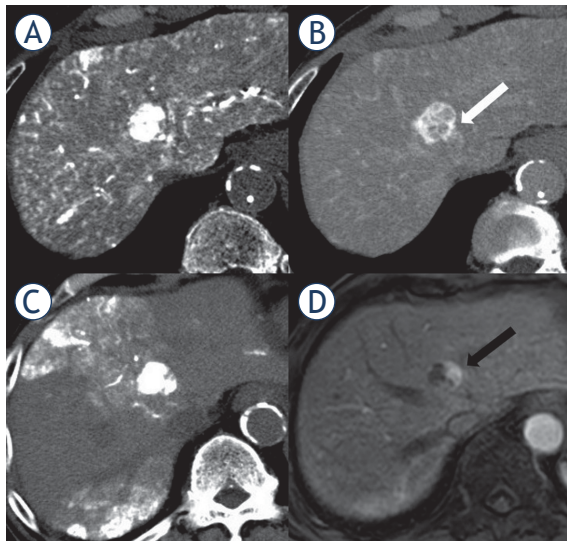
Local tumor recurrence after transcatheter arterial chemoembolization (TACE) in an 82-year-old patient with a hepatocellular carcinoma. (A) Early-phase computed tomography during hepatic arteriography (CTHA) demonstrated a hypervascular nodule in S5. (B) Late-phase CTHA demonstrated the corona enhancement around the tumor (white arrow). (C) Non-contrast-enhanced computed tomography performed immediately after TACE showed dense accumulation of iodized oil throughout the tumor, but not in the entire corona enhancement area. (D) In contrast enhanced magnetic resonance images obtained 4 months after TACE, local recurrence developed around the tumor (black arrow).
